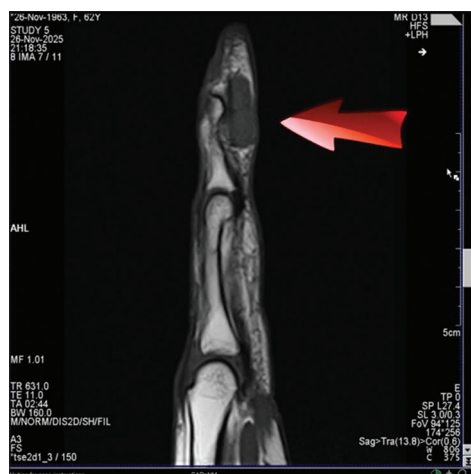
Magnetic resonance imaging showing a well-circumscribed lesion in subungual region
